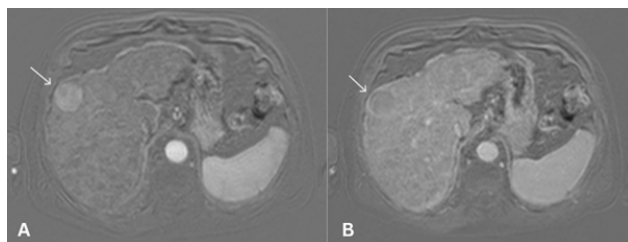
(A) T1-weighted image post-contrast with subtraction showing a 35 mm nodule in the hepatic segment VIII with heterogenous arterial enhancement (arrow). (B) T1-weighted image post-contrast with subtraction showing the same nodule with portal venous washout and pseudocapsule (arrow), findings that are compatible with HCC.
